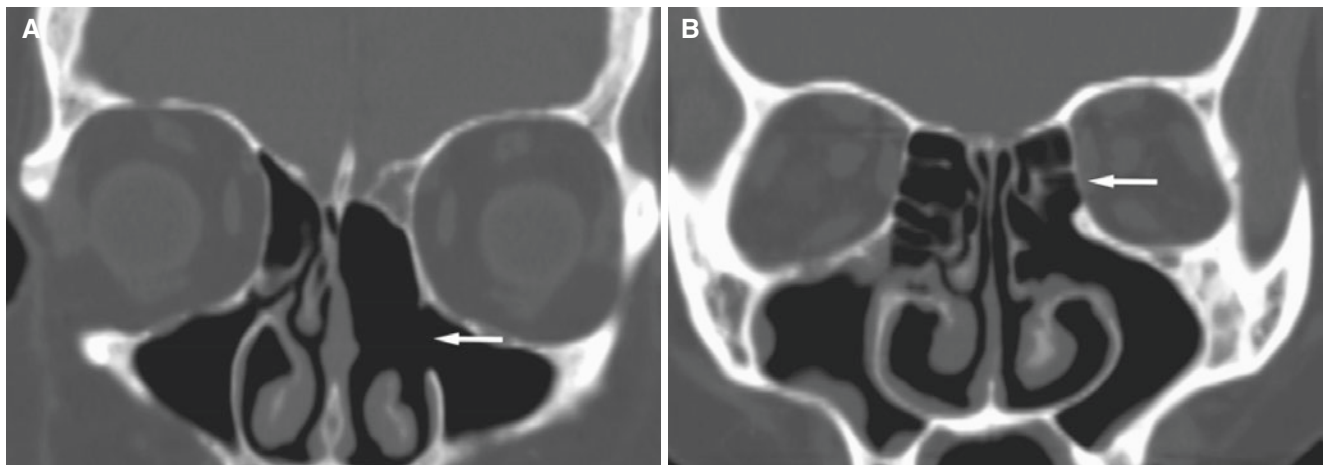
Post endoscopic surgery; 41-year-old female 9 years after septoplasty with left concha bullosa and partial ethmoid sinus resection, now with “nose problem.” (A) Coronal CT image shows that the left medial maxillary sinus wall is removed (arrow), together with the left
